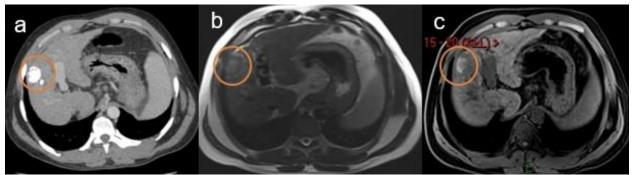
a and b. Figure 5a shows concentrated lipiodol in a lesion on CT scan. Figure 5b axial non contrast T1 fat-suppressed image showing lipiodol within the lesion appears as low signal intensity on T1 fat suppressed sequence.
